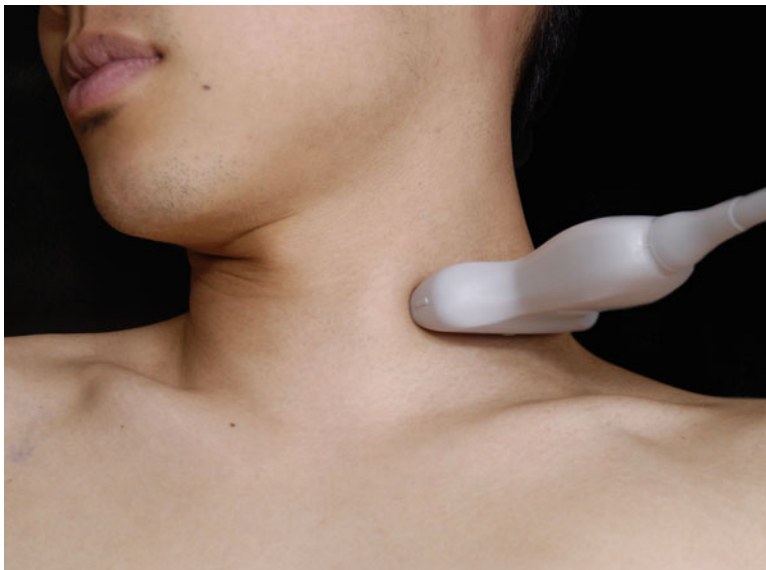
Position of the ultrasound probe for interscalene brachial plexus block
